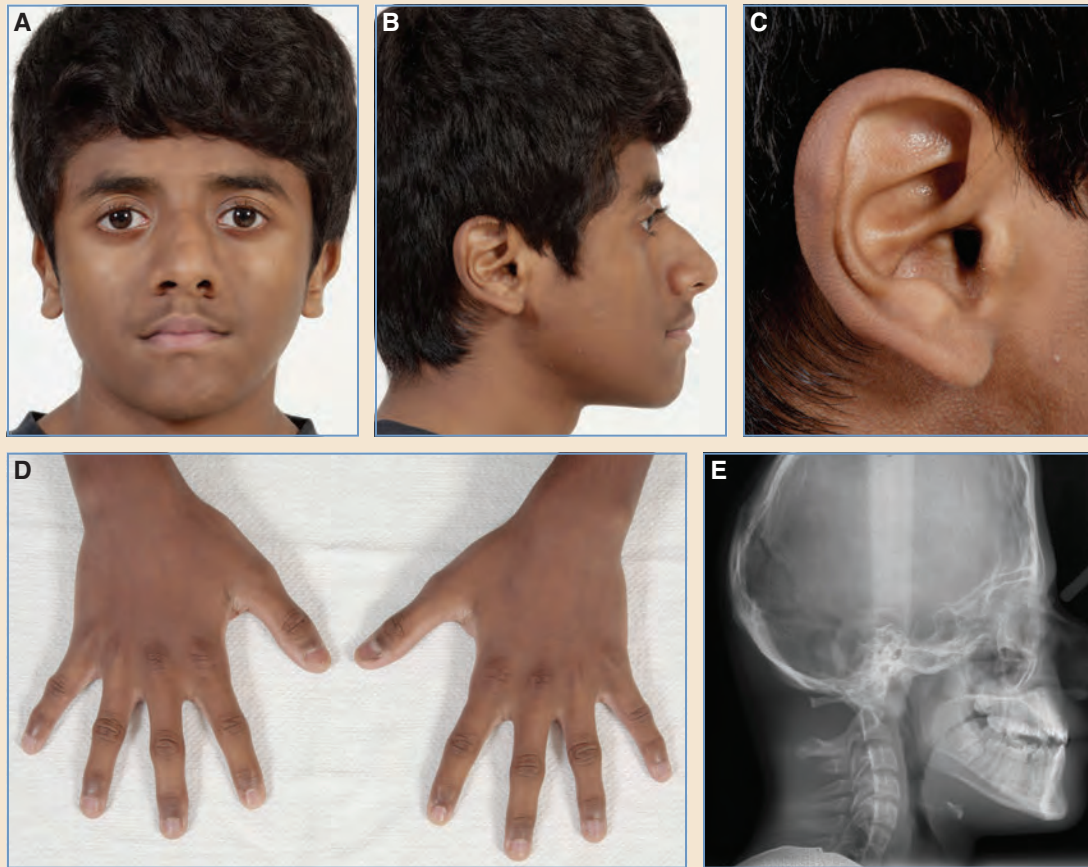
A and B, This 13-year-old boy has Saethre-Chotzen syndrome, characterized by mild upper lid ptosis, turribrachycephaly from bicoronal synostosis, and supraorbital rim retrusion. C, His ears have characteristic prominent superior crura. D, There is evidence of bilateral simple syndactyly of the fingers. E, A lateral cephalometric radiograph shows a tall, retruded forehead; fusion of both coronal sutures; and a class I dental and skeletal relationship.
